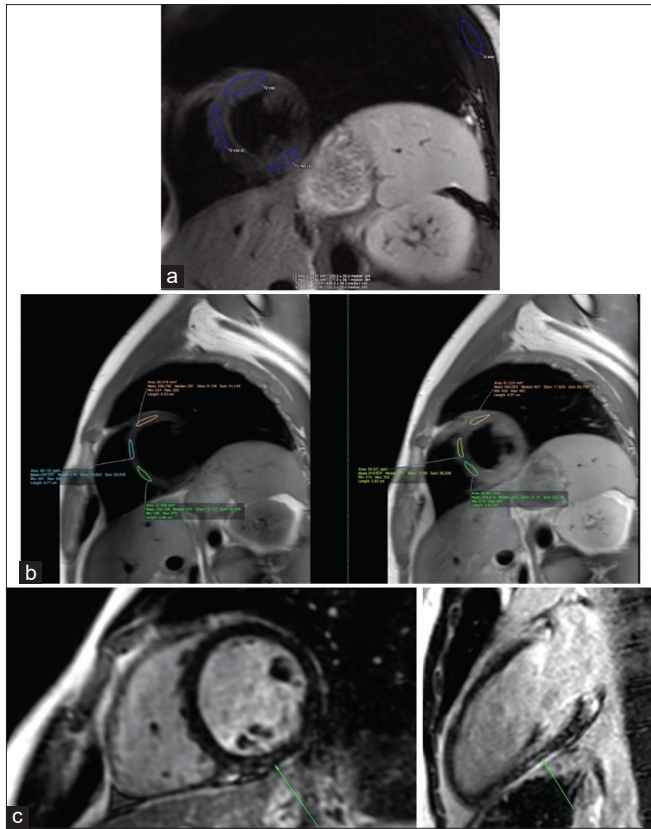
CMR with original Lake Louise Protocol Case 1. (a) T2-weighted black-blood sequence with >2:1 increase in myocardial signal intensity compared to skeletal muscle at the mid-LV, anterior wall. Positive findings were consistent with myocardial edema. (b) T1-weighted TSE sequence with >45% increase in signal intensity postcontrast at the mid-LV. Positive for early gadolinium enhancement, indicating hyperemia. (c) Late-gadolinium enhancement, signifying fibrosis or scar (green arrow), was noted on several slices at the LV inferior wall. CMR: Cardiac magnetic resonance imaging, TSE: Turbo spin echo, LV: Left ventricular
